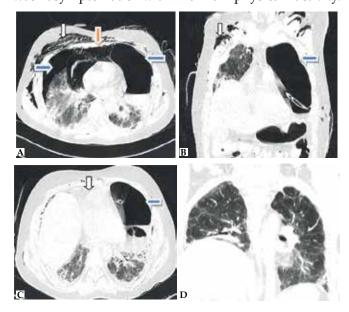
Computed tomography of the chest with lungs window: (A) axial image of day-18 hospitalisation showing subcutaneous emphysema (white arrow), bilateral pneumothorax (blue arrows), and pneumomediastinum (yellow arrow); (B) coronal and (C) axial images after 72 hours of pigtail and intercostals drainage insertions showing significant improvements with the persistence of the left side pneumothorax (blue arrow) and minimal emphysema (white arrow); (D) coronal image showing resolution of air pockets with remnant fibrotic bands at three months of follow-up.
